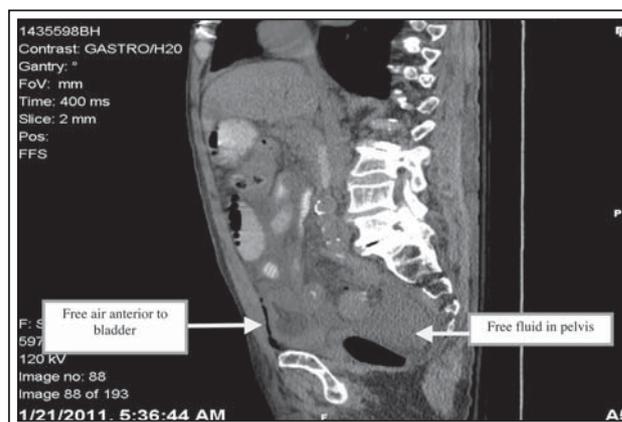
CT scan showing free intraperitoneal air anterior to bladder.
